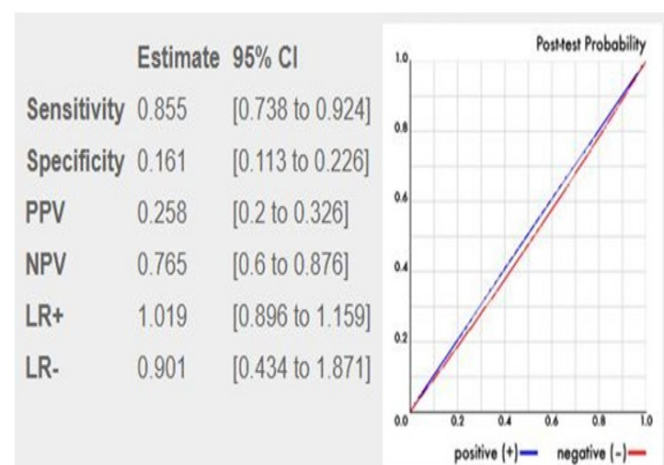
Sensitivity, specificity, PPV, and NPV values indicating the success of the OAR in predicting the need for radiography
